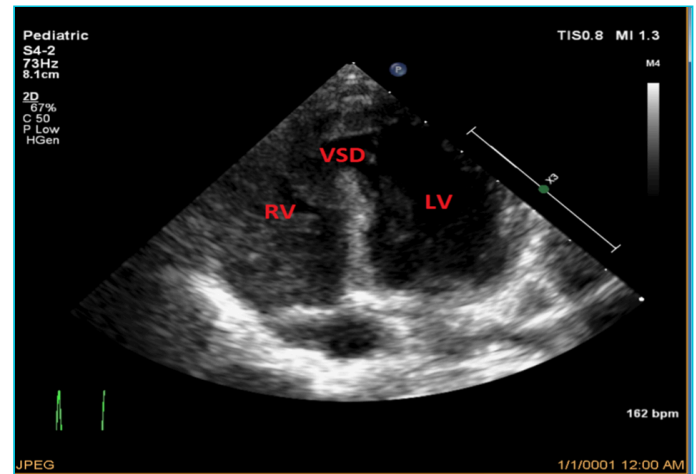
A newly developed ventricular septal defect (VSD) is shown in the echocardiography image taken in the apical 4-chamber plan.
